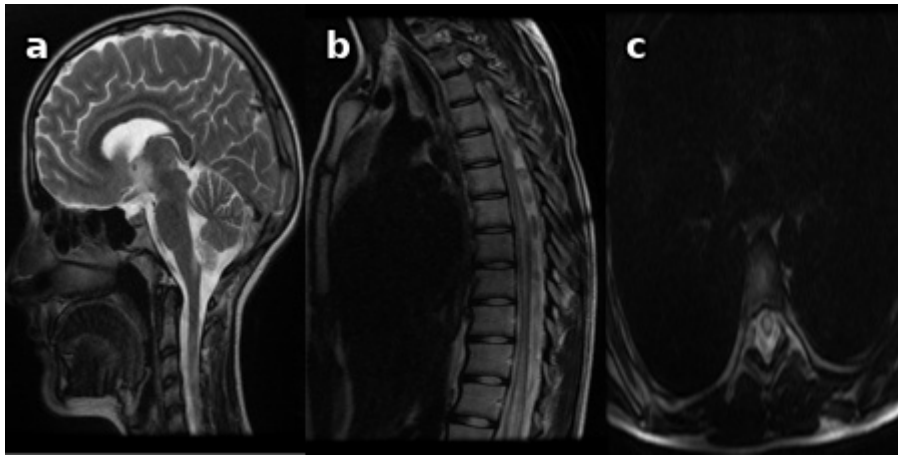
Sagittal and axial T2-weighted MRI images demonstrate hyperintense signal changes involving the (a) hypothalamus, mammillary bodies, periventricular region surrounding the third ventricle, area postrema at the level of the medulla oblongata, and the upper cervical spinal cord; (b) longitudinally extensive hyperintense signal changes extending from the T4 level to the conus medullaris on sagittal spinal imaging; and (c) central hyperintense signal changes within the spinal cord on axial T2-weighted images.
